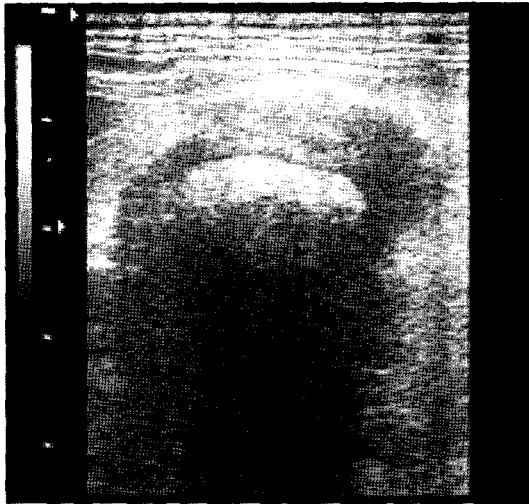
Ultrasonographic appearance of the abdominal granuloma in case 2. An oval marked hypoechoic mass containing hyper-echoic center was shown. A strong acoustic shadow was present deep to the mass.
